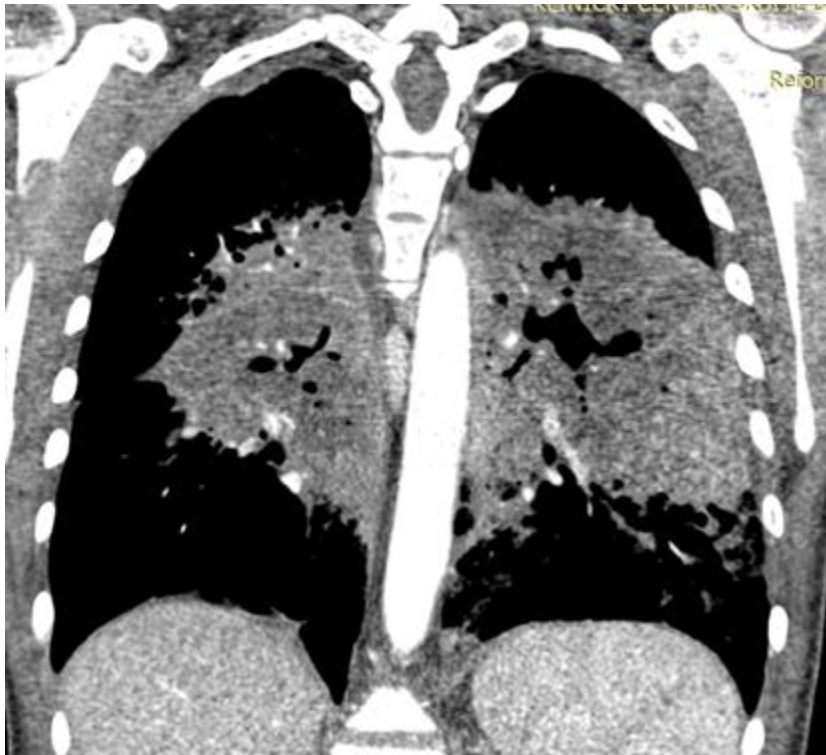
Coronal computed tomography view in soft tissue window setting in female patient with granulomatosis with polyangiitis shows irregular parenchymal consolidation with a cavitation in the both lungs
